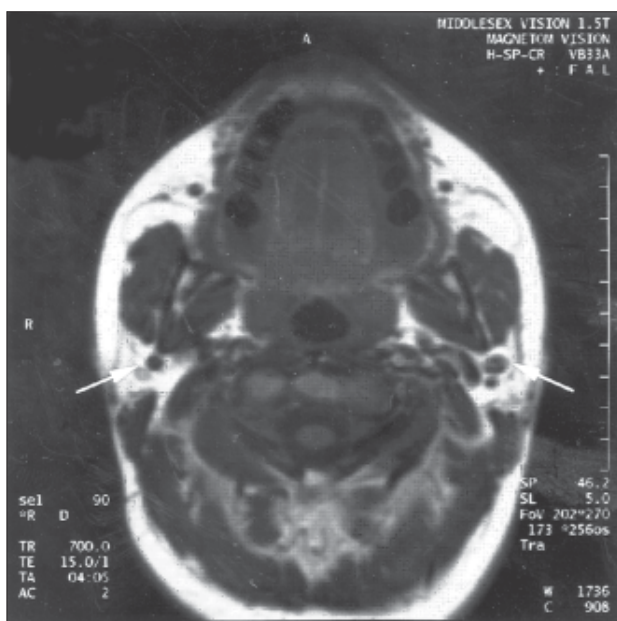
Transverse MRI scan at the level of the ramus of the mandible. The arrows indicate the sites of the absent parotid glands.
